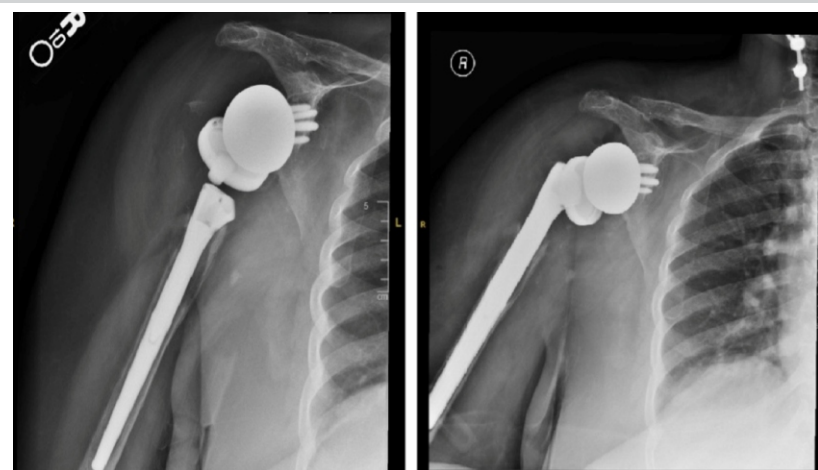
Anteroposterior radiographs of the right shoulder in December 2020. Radiographs demonstrate loosening of the humeral stem with subsidence and dissociation of humeral cup from metaphyseal segment (left), followed by subsequent revision of the humeral component resulting in appropriate alignment (right).
